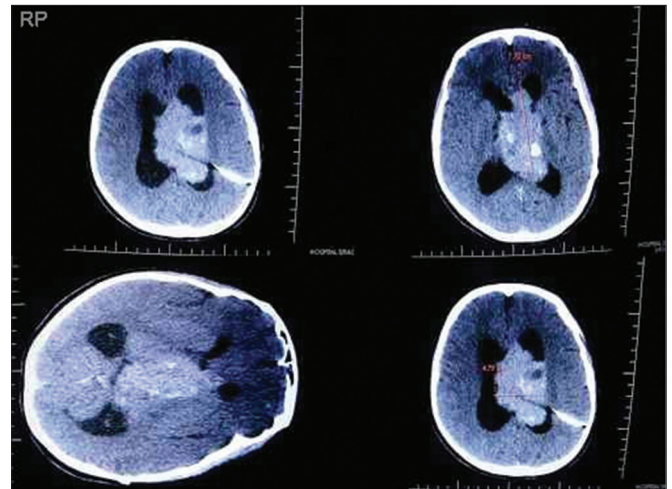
Central Neurocytoma: CT shows a large mass, with moderate contrast enhance, in the third ventricle and lateral ventricles, measuring about 78 x 48 mm. There is a hypodense area in between. Hydrocephalus is attenuated by a ventricular derivation.
